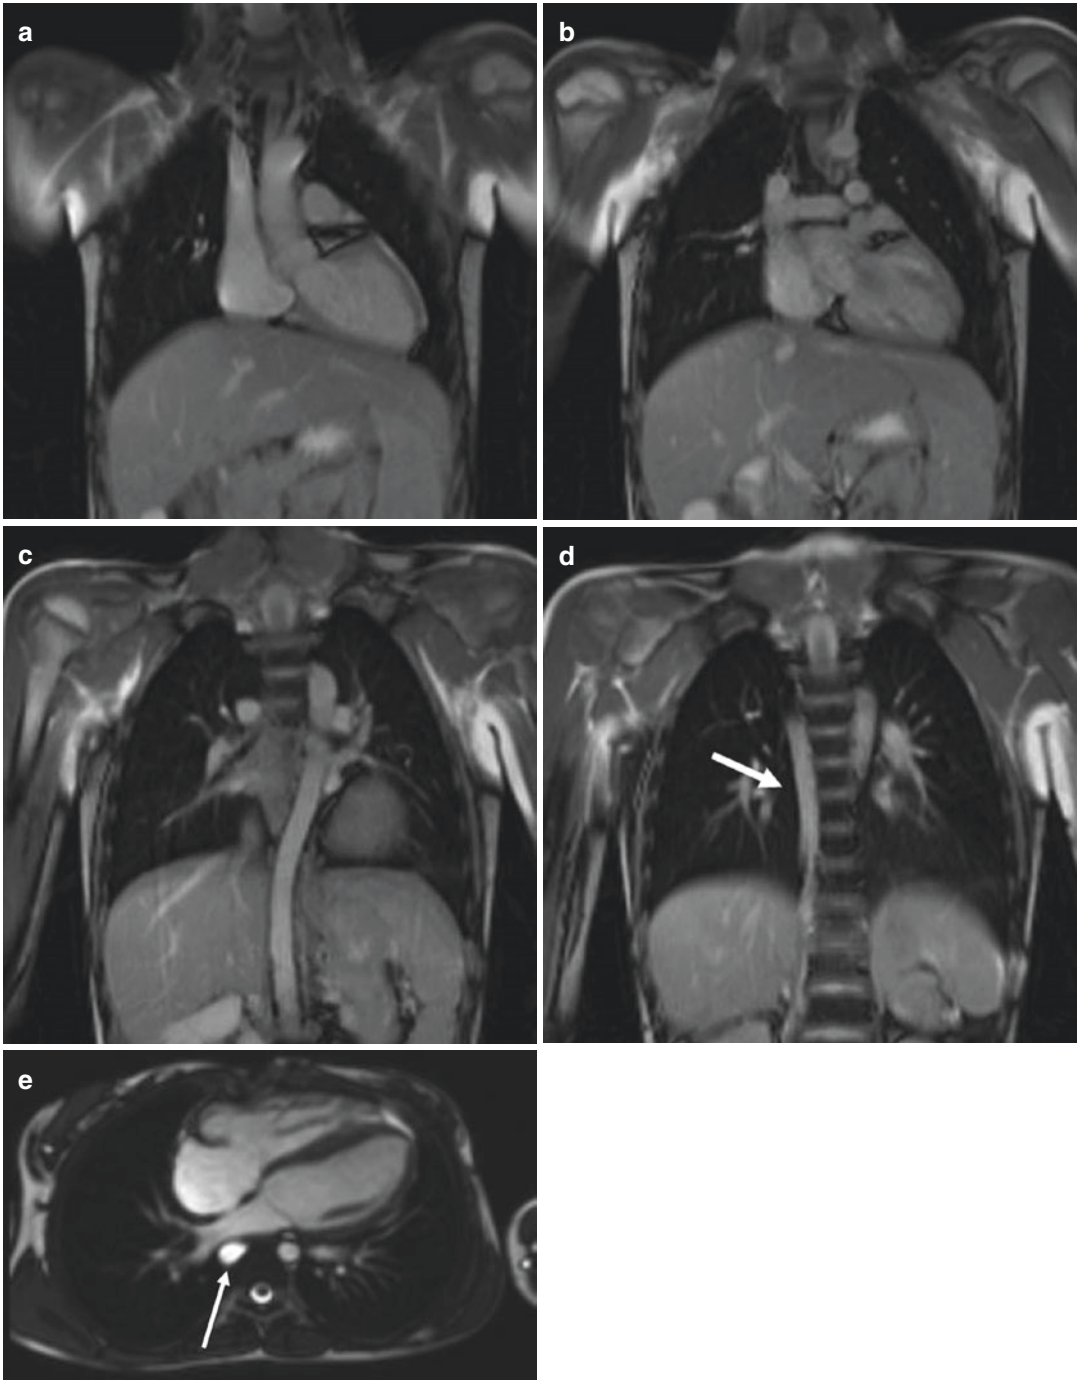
Interruption of inferior vena cava with azygos continuation (*white arrows*) on (a)–(d) coronal TruFISP and (e) on four-chamber view cine TruFISP MRI sequence images
